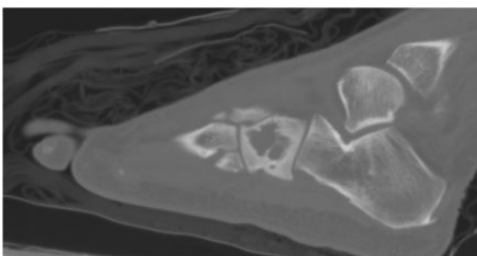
Sagittal view on computed tomography (CT) scan of the injured right foot showing an osteolytic lesion over the cuboid bone. No visible foreign body was observed over the plantar region.
